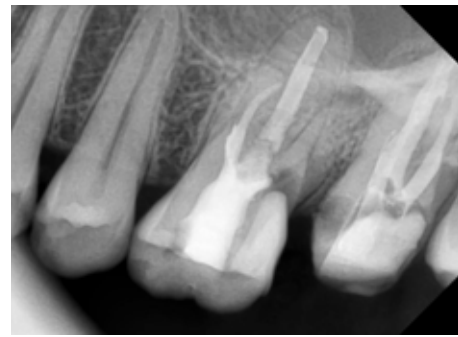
Pre-operative radiograph. Cervical caries seen extending in to the pulp space of disto-buccal root
